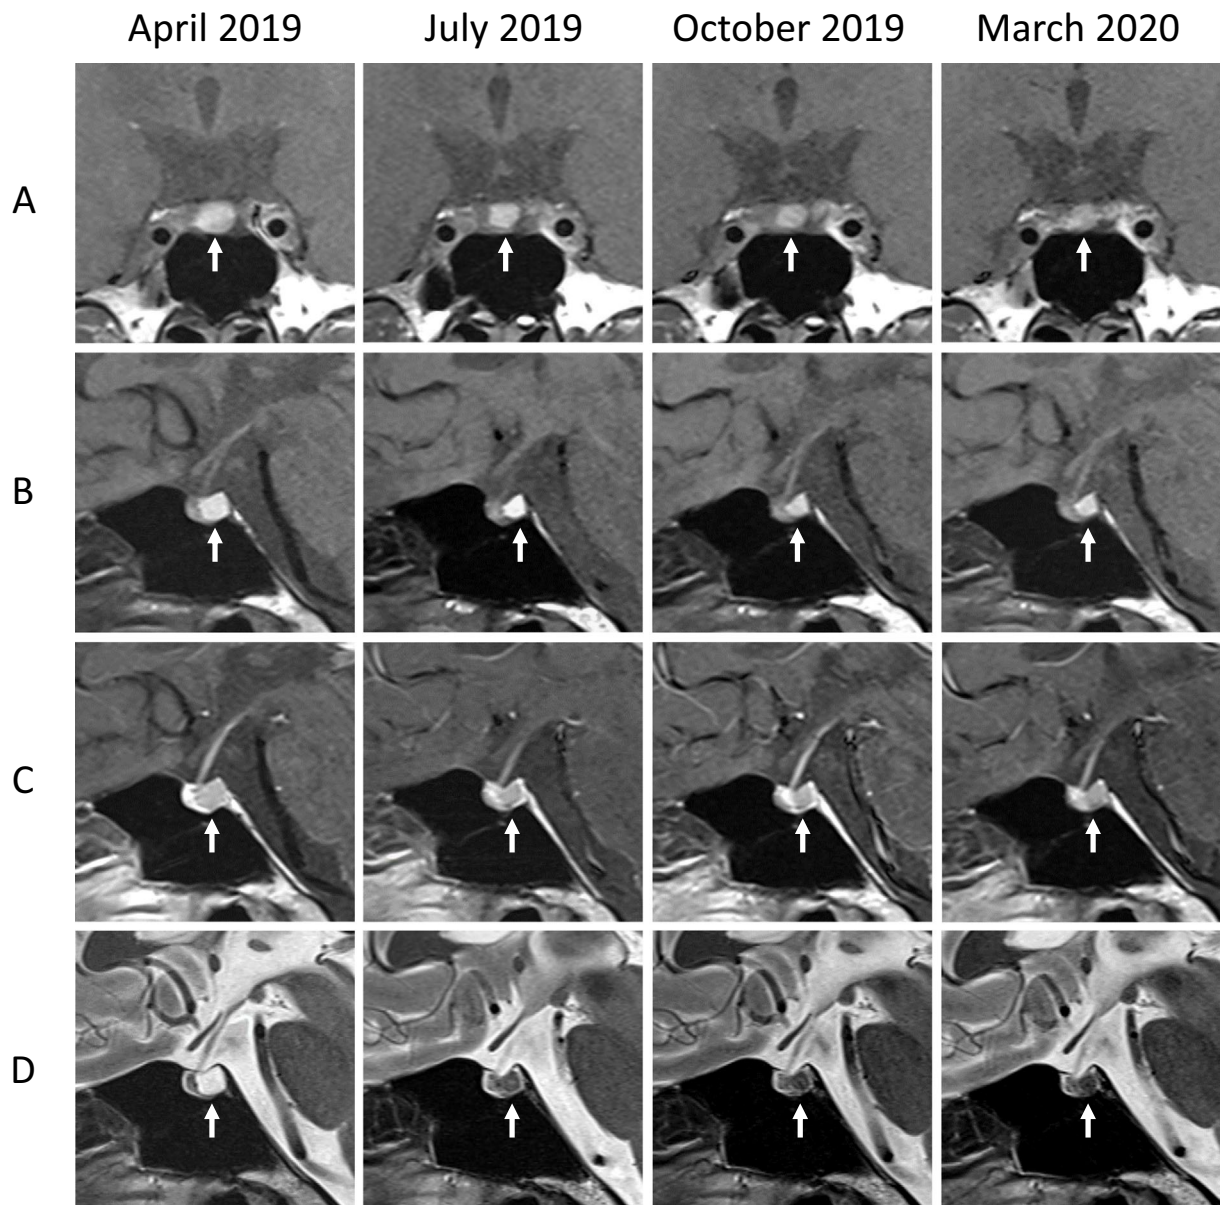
Serial magnetic resonance imaging of the pituitary gland. A: T1-weighted sagittal, B: T1-weighted coronal, C: gadolinium-enhanced T1-weighted sagittal, and D: T2-weighted sagittal images. The greatest diameter of the patient's pituitary cystic lesion at different timepoints was 9 mm (April 2019), 7 mm (July 2019), 7 mm (October 2019), and 7 mm (March 2020).
